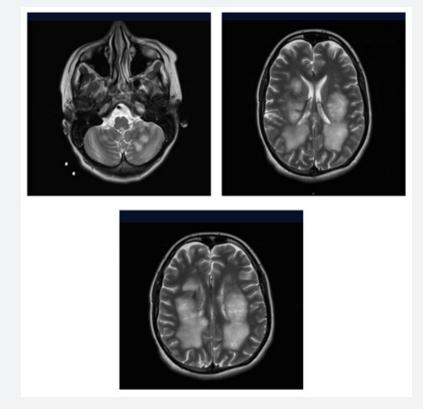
Repeat MRI showing worsening of lesions compared to previous.
